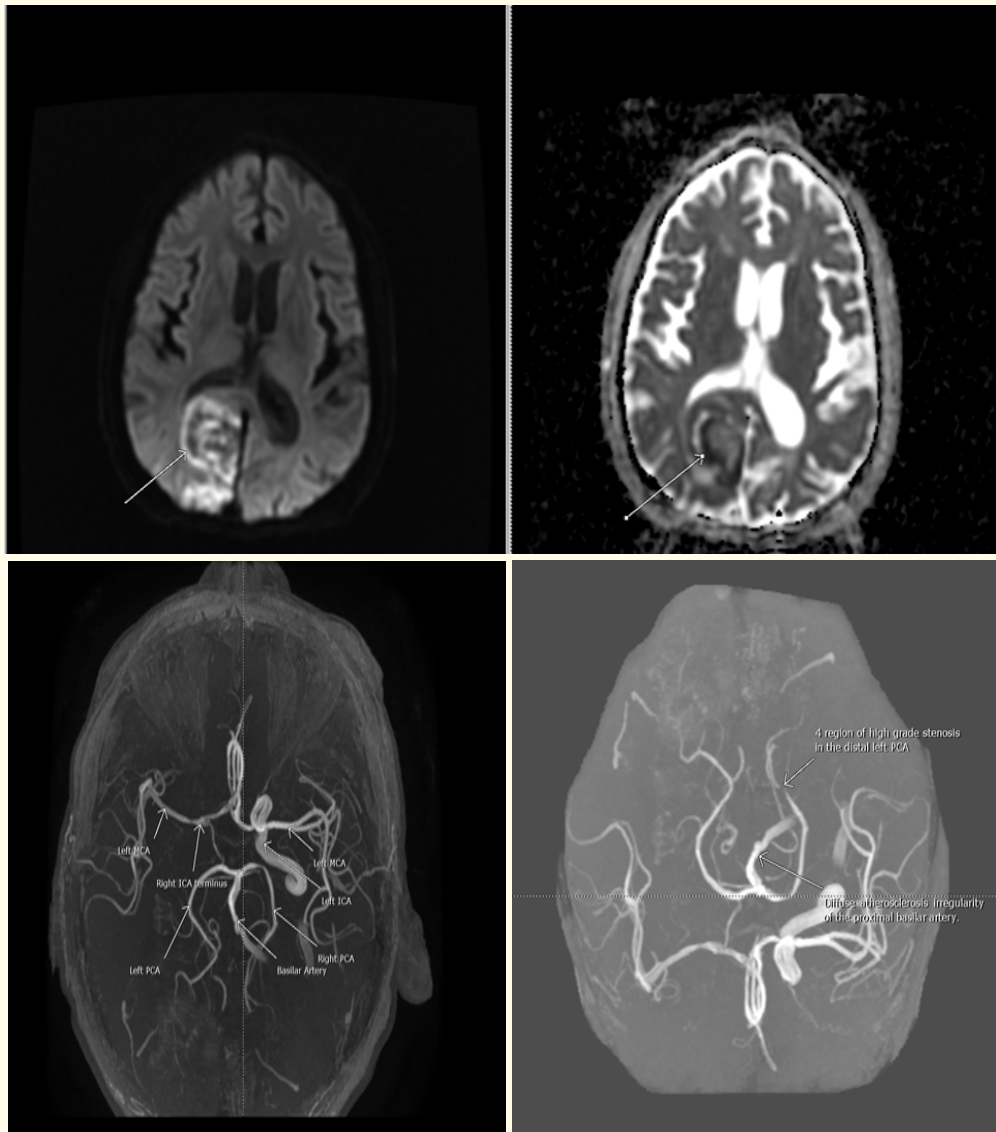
A (DWI) and B (ADC) Acute left PCA territory infarction with hemorrhage transformation in left occipital lobe as depicted by the arrows.
